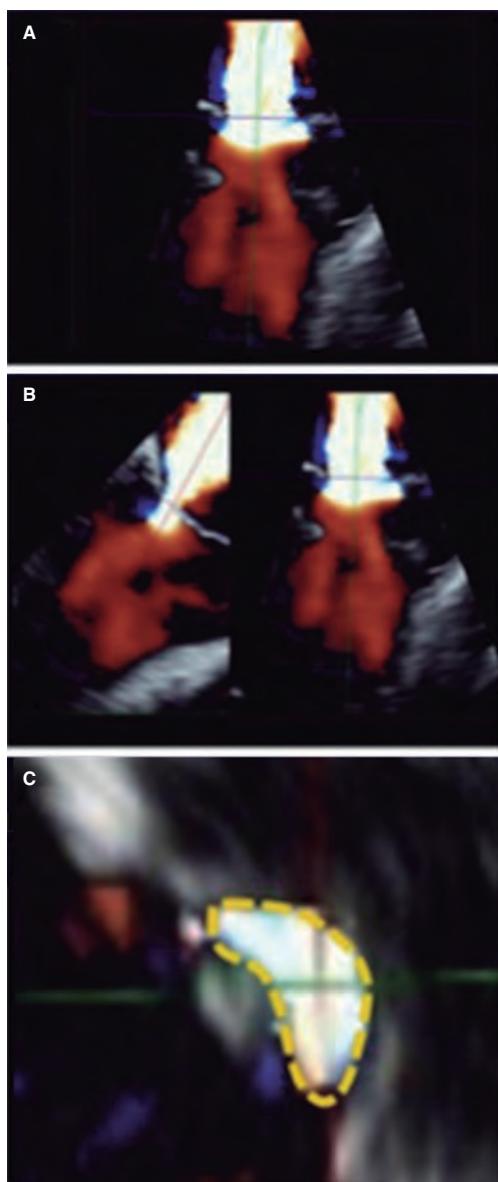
Two-dimensional transesophageal echocardiography image for the assessment of the vena contracta area. A: 3D color Doppler echocardiography of residual mitral regurgitation after clip implantation. B: axis alignment to obtain the 3D-guided vena contracta area. C: 3D-guided planimetry sketch. Reproduced with permission from Avenatti et al.¹³.
